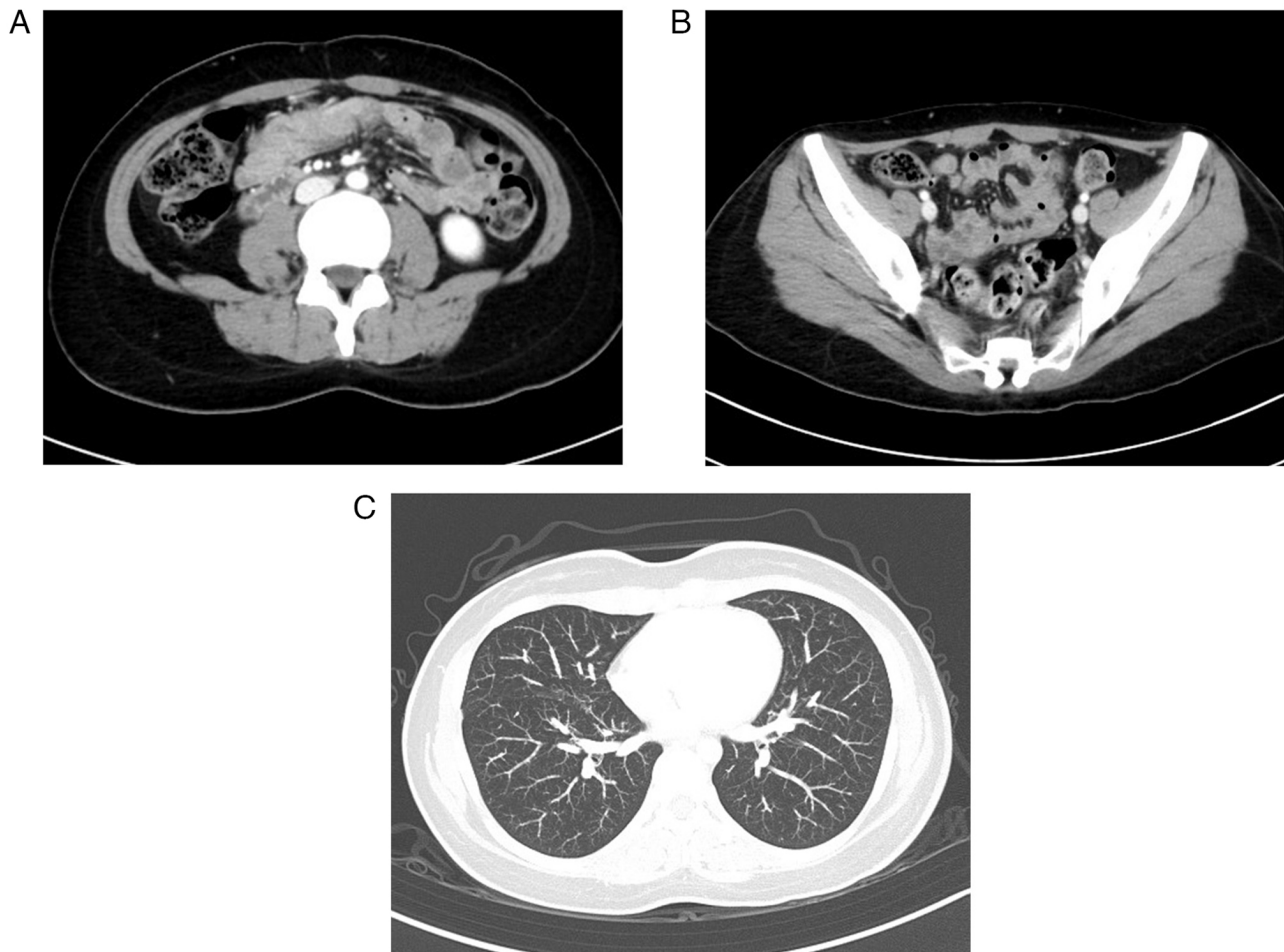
Treatment response on computed tomography. (A) Resolution of the previously enlarged para-aortic lymph nodes. (B) Resolution of the previously enlarged pelvic lymph nodes. (C) Disappearance of multiple pulmonary nodules. These findings were consistent with a complete response.
